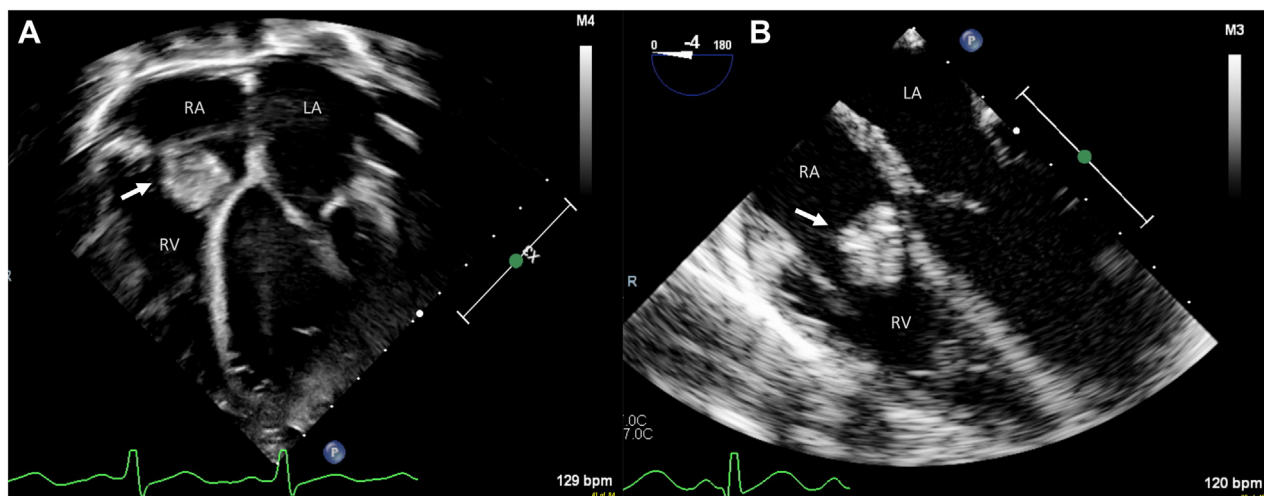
Two-dimensional transthoracic echocardiogram in the 4-chamber view (A) and two-dimensional transesophageal echocardiogram mid-esophageal, RV-focused 4-chamber view (B) in mid-diastole demonstrate mild biventricular dilation and a large echobright mass (arrow) in the RA crossing the plane of the TV. LA, Left atrium.
